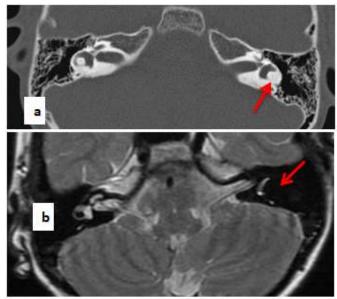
a) Axial HRCT image shows ossification of left lateral semicircular canal(red arrow). b) Axial T2 MR image shows loss of bright Signal in left semicircular canal
